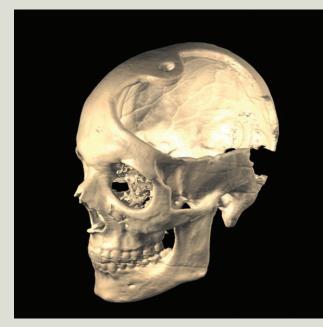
Three-dimensional CT of patient s/p craniectomy.
